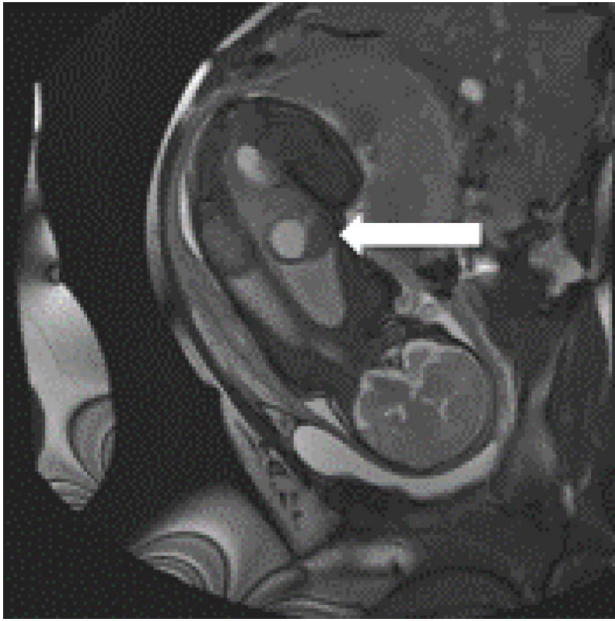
Cystic adrenal mass identified on a non-contrast fetal MRI obtained at 36 weeks and 2 days of gestation. The white arrows are pointing to a 3.1×3×2.8 cm lesion in the left adrenal gland.
